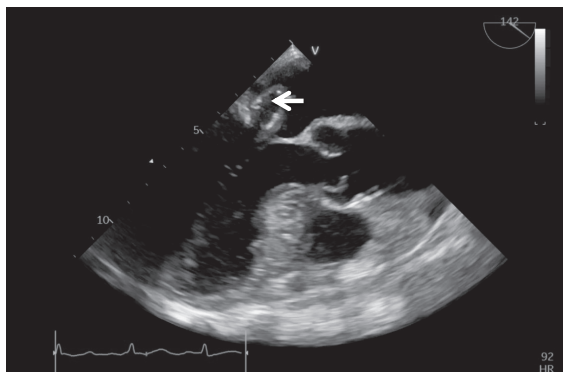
A fluttering perforated aneurysm on the Posterior mitral valve leaflet (1.6.2.5 cm, white arrow) in the long parasternal view of transesophageal echocardiogram
